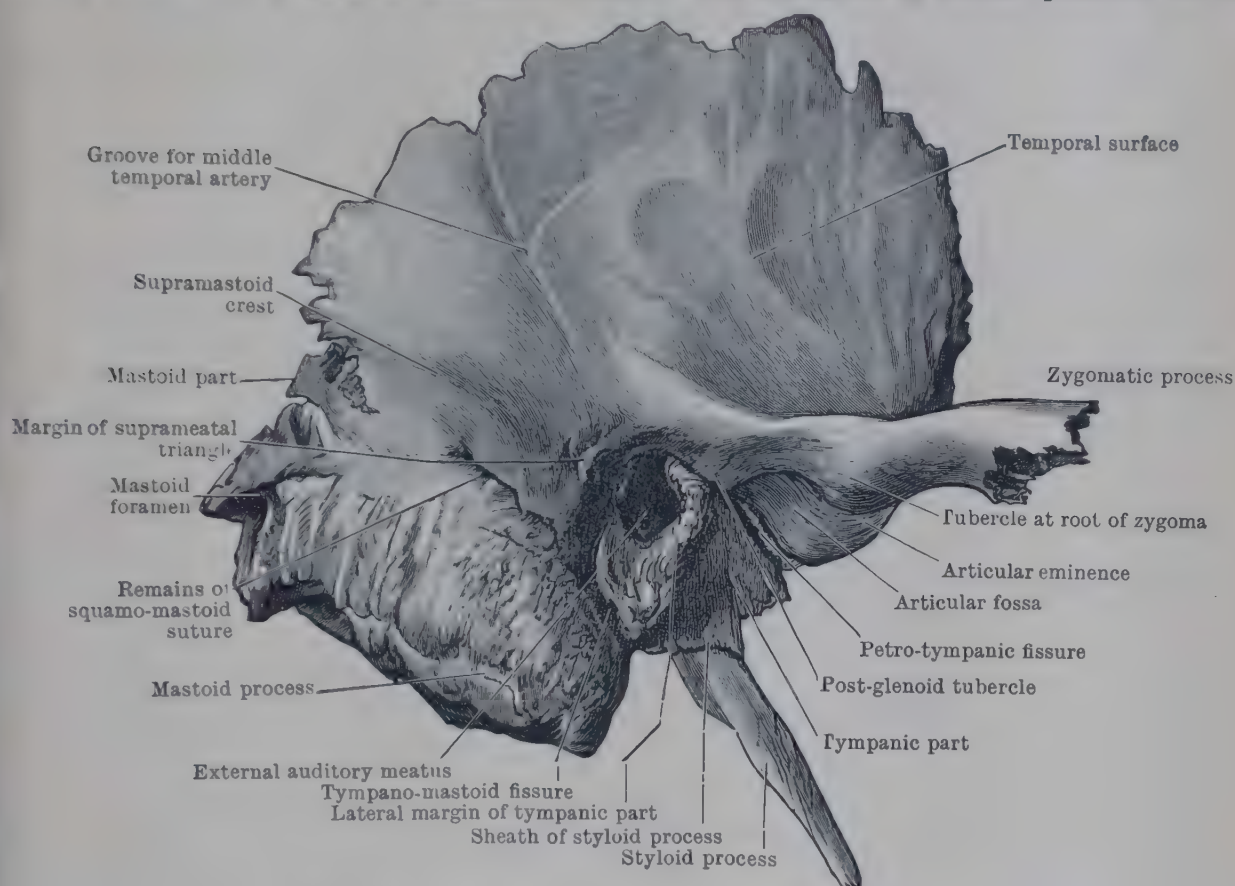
LATERAL ASPECT OF RIGHT TEMPORAL BONE.
